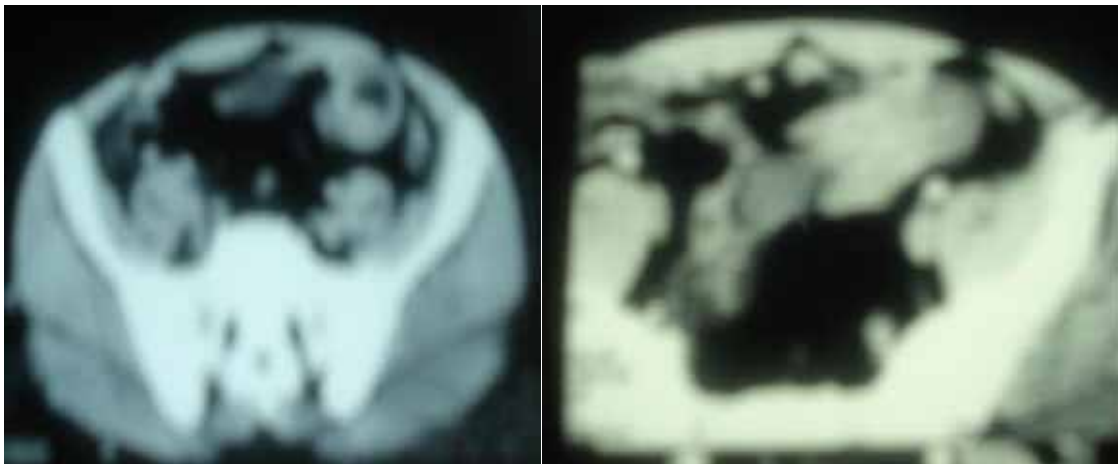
Abdominal computed tomography in adult intussusception.
